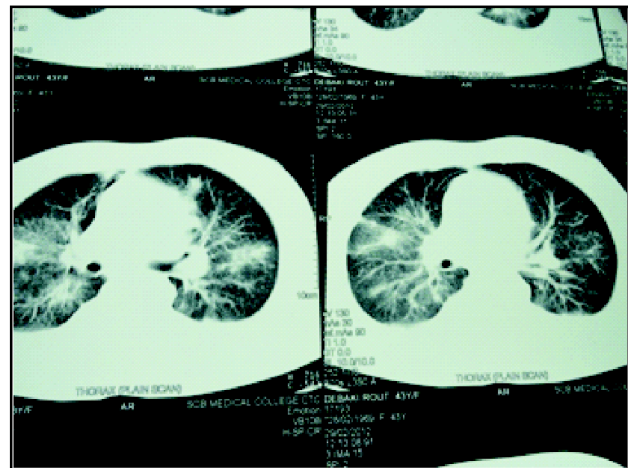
HRCT thorax showing multiple nodular opacities over bilateral lung fields. (Case-1)
